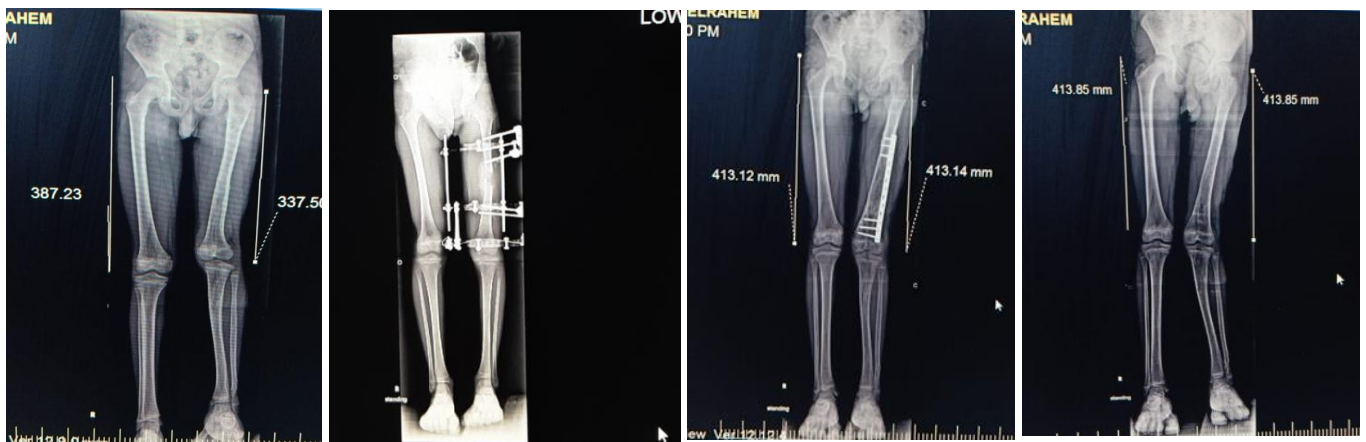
Radiograph of 11years old male with 5 cm left femoral shortening was treated by LAP.
